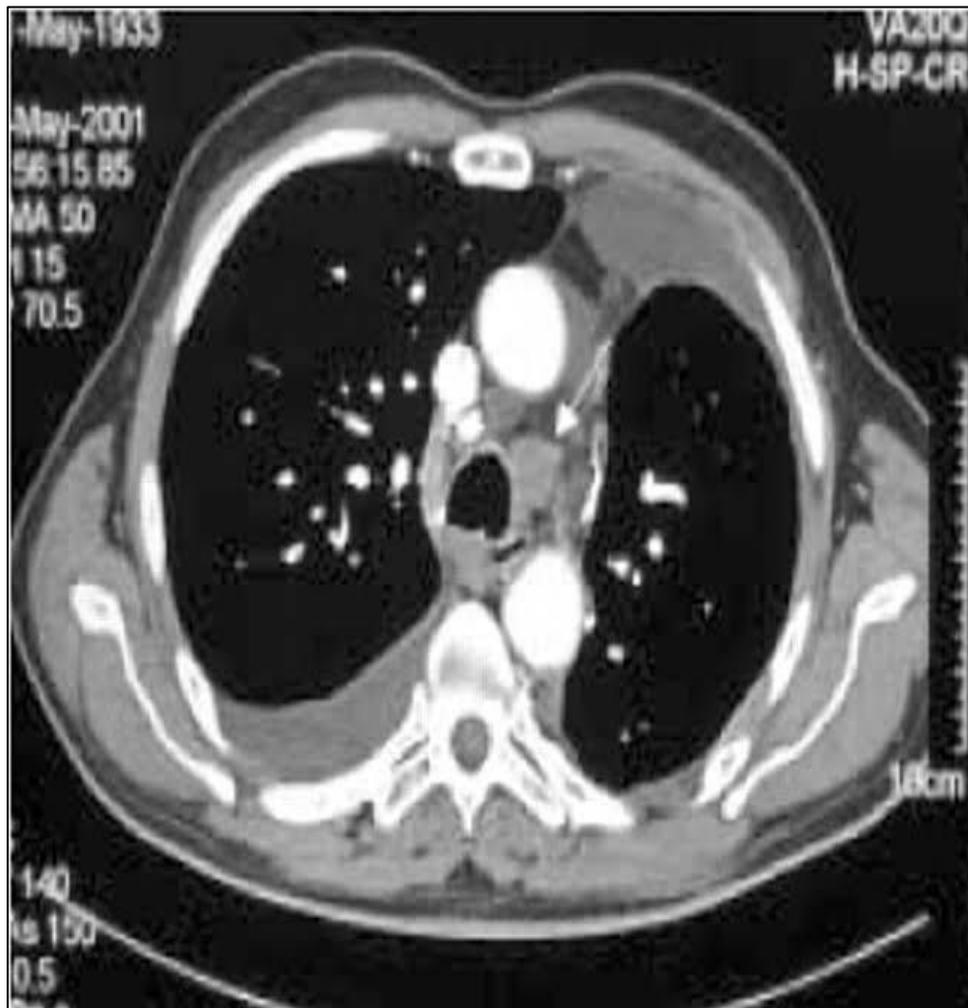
Staging of lung cancer: CT image [32]
